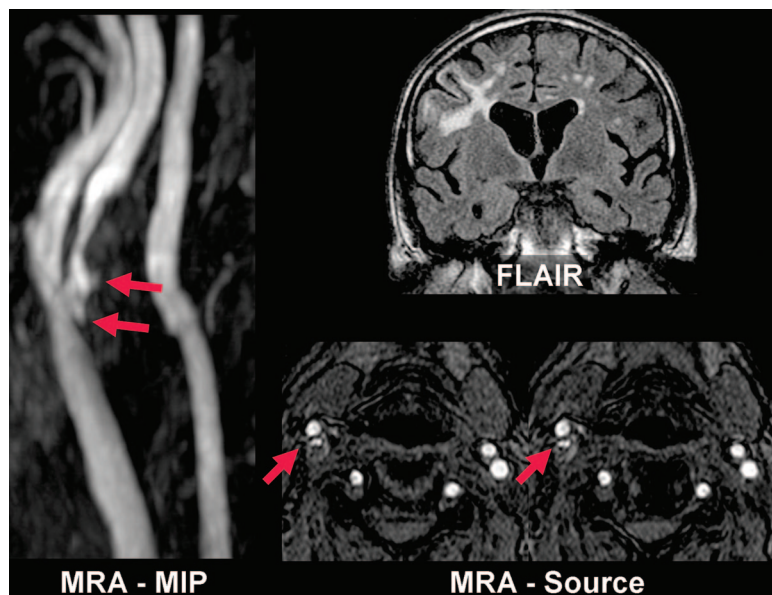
Noncontrast 3-dimensional time-of-flight MRA in right carotid atherosclerosis. The degree of narrowing is only 70% by NASCET criteria, but there are also signs of plaque ulceration (arrows) and deep carotid watershed distribution ischemic changes on coronal FLAIR (fluid-attenuated inversion recovery) images. MIP indicates maximum-intensity projection.
